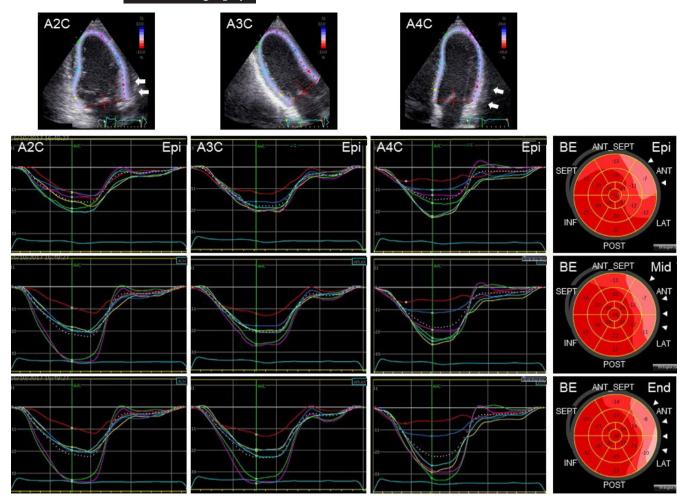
Example of layer-specific strain curves measurement by 2D-speckle tracking echocardiography in a hypertrophic cardiomyopathy patient with mild thickening (15 mm) at the anterior and lateral segments of the left ventricular wall (arrow). At the bull's eye (right panel), all layers strain values (arrowhead), which are corresponding to mild thickened area. A2C, apical 2-chamber; A3C, apical 3-chamber; A4C, apical 4-chamber; BE, bull's eye of the layer-specific strain; End, endocardial strain; Epi, epicardial strain; Mid, mid-myocardial strain
